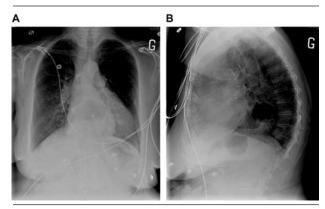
Chest radiograph from a 72-yr-old woman with an esophageal hernia. Air shadows can be seen in the middle of the chest (A) and behind the left atriun on the lateral view (B). (Courtesy of Dr. Patricia Ugolini).
